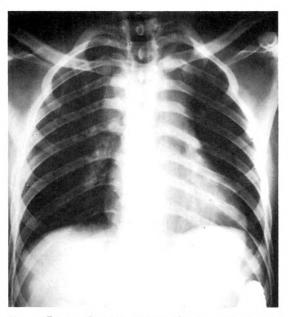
Case II. Roentgenogram shows a tumor mass of the right paratracheal area with fullness in the space beneath the aortic knob and both hilar areas. Bilateral lymphadenopathy was strongly suggested.
